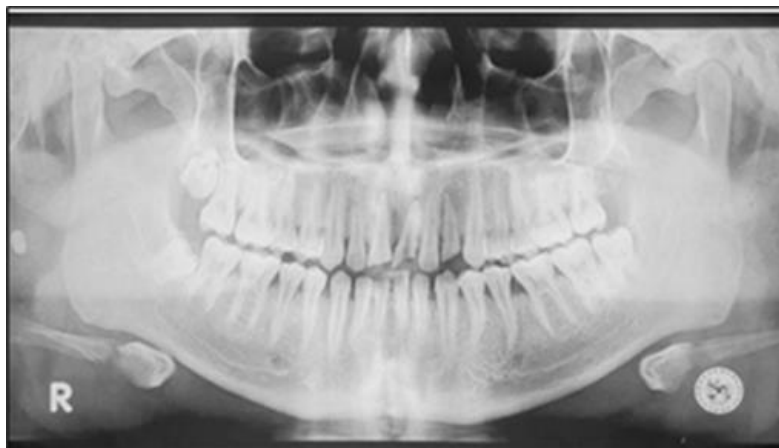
Panoramic radiography
